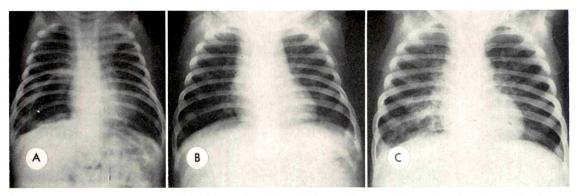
Chest roentgenograms of a white male child at (A) 3, (B) 9 and (C) 15 months of age. Cough was noted commencing at the age of 5 weeks. (A) At 3 months the patient was infected with Staphylococcus pneumonia which produced a large pneumatocele. (B) He recovered, and the lungs cleared. (C) Six months later, however, he had further pulmonary infection and died.
